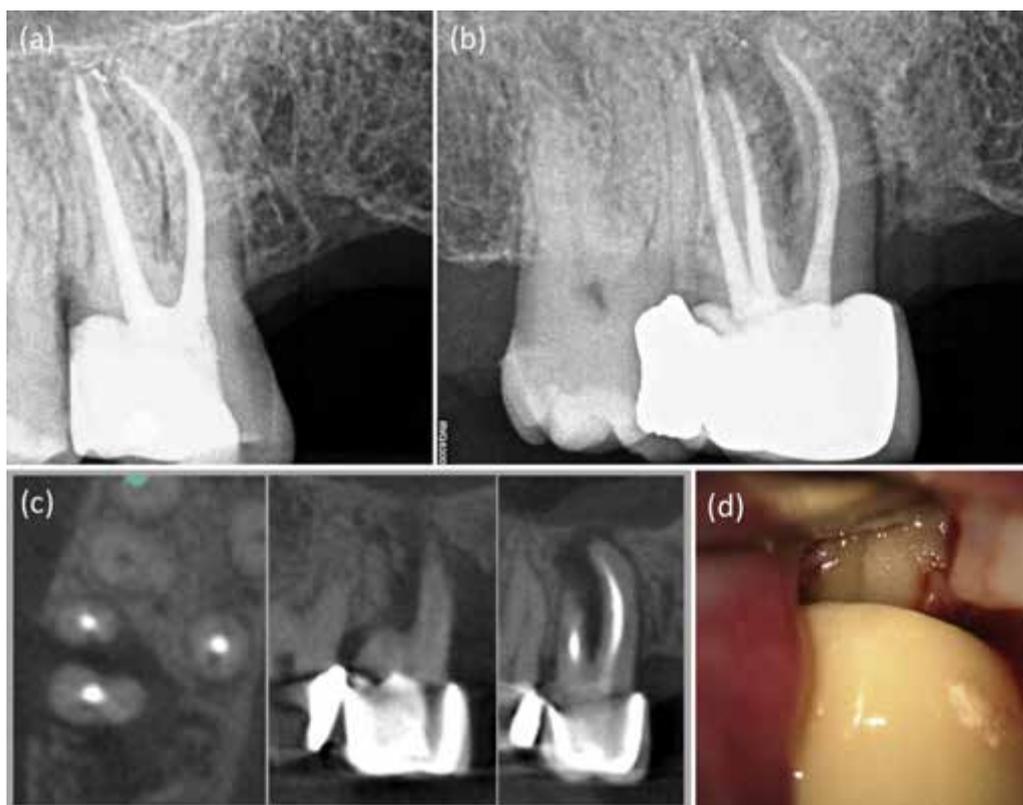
Example images of a right maxillary first molar (tooth 16): (a, b) digital periapical radiographs, and (c) reconstructed axial cone beam computed tomography (CBCT) (CS 9000 3D; Carestream Health, Rochester, NY, USA) slices. The fracture was not visible on either imaging modality. (d) The suspected vertical root fracture was only confirmed during the surgical flap procedure.
